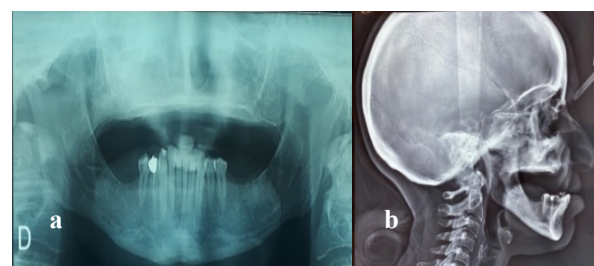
Preoperative radiographs; a) Panoramic radiograph, b) Profile telerradiograph.
